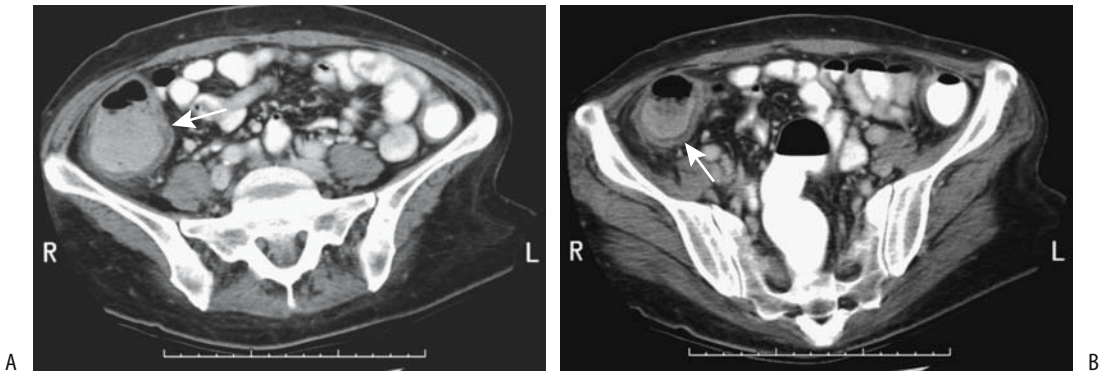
Cytomegalovirus colitis. A,B: Two pelvic CT images reveal a dilated, thick-walled colon (arrows). Pseudomembranous colitis is in the differential diagnosis. (Courtesy of Patrick Fultz, M.D., University of Rochester.)
